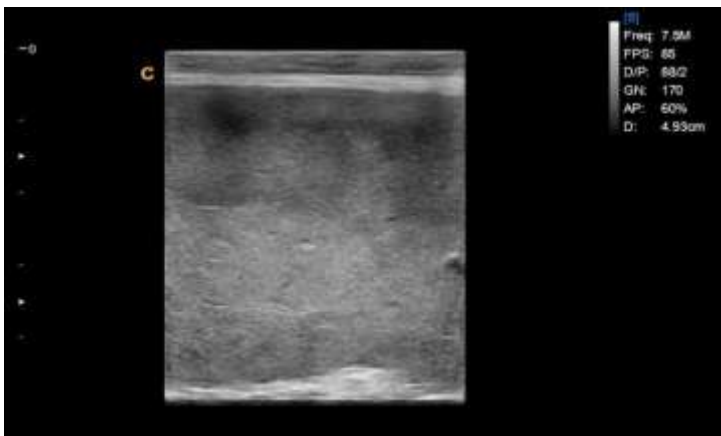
Sonogram showing splenomegaly with homogenous parenchyma.
